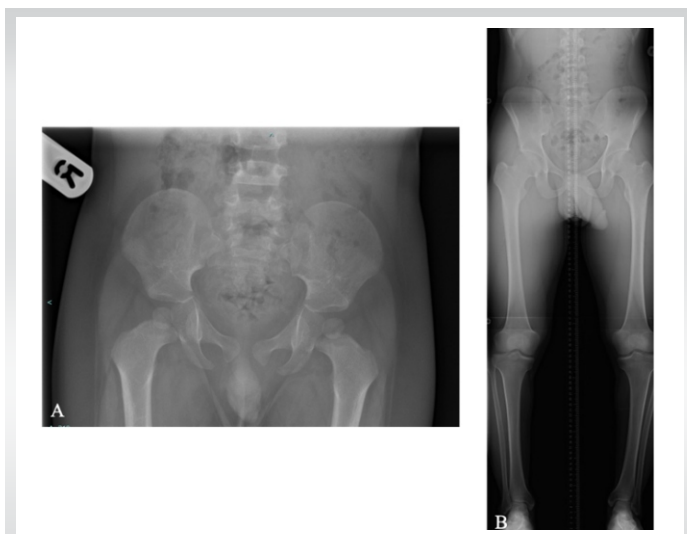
Radiographic features of hypochondroplasia (A-B) A: Pelvic radiograph of a grade schooler demonstrating short iliac bones with flat acetabular roofs and wide-appearing proximal femoral diaphysis. B: Leg length radiograph demonstrating subtle decrease in the interpedicular distance from first to fifth lumbar vertebrae, flat acetabular roof, mild flaring of metaphyseal-epiphyseal junction of the femurs and tibiae, short and broad femoral necks and rectangular proximal tibial epiphyses.
